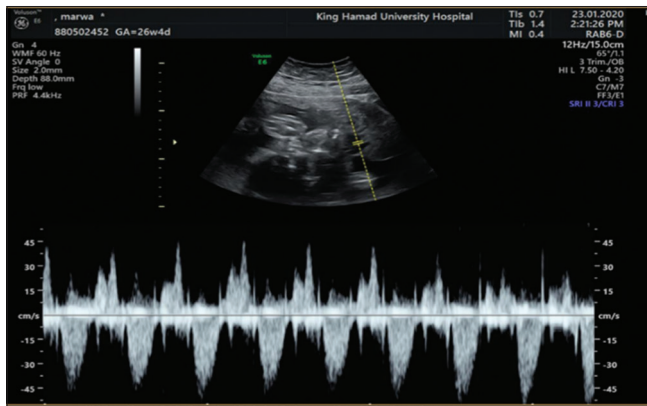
Ultrasound showing positive fetal heart beats at 26 weeks
